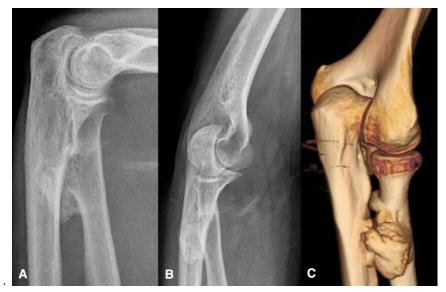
Xray left side elbow showing proximal radio ulnar synastosis and CT scan of left elbow shows synostotic bridge
